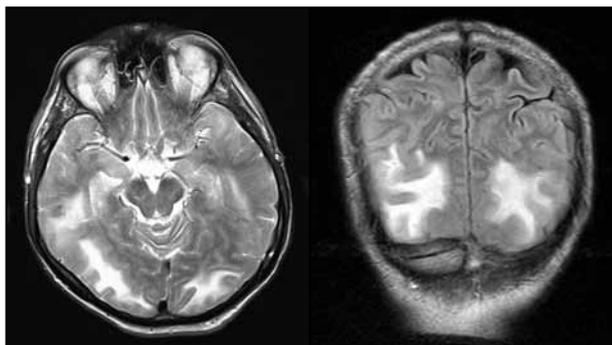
T2-weighted magnetic resonance scans of the brain of a 55-year-old man showing bilateral symmetrical white matter oedema in the parieto-occipital lobes typical of posterior reversible encephalopathy syndrome associated with deoxycoformycin and alemtuzumab.
